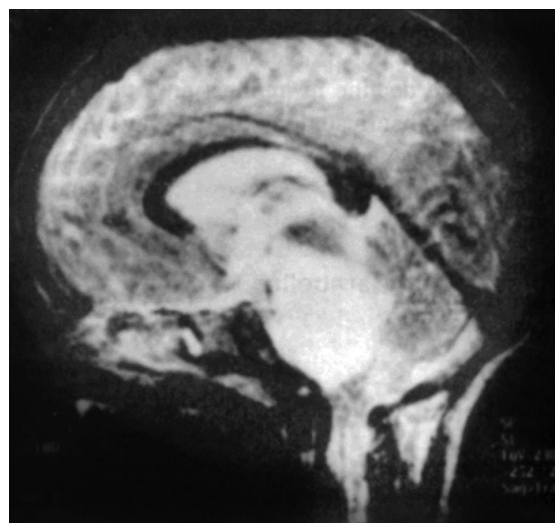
Glioma. Magnetic resonance imaging of a solid brainstem glioma which is the third most common posterior fossa tumor of childhood.
